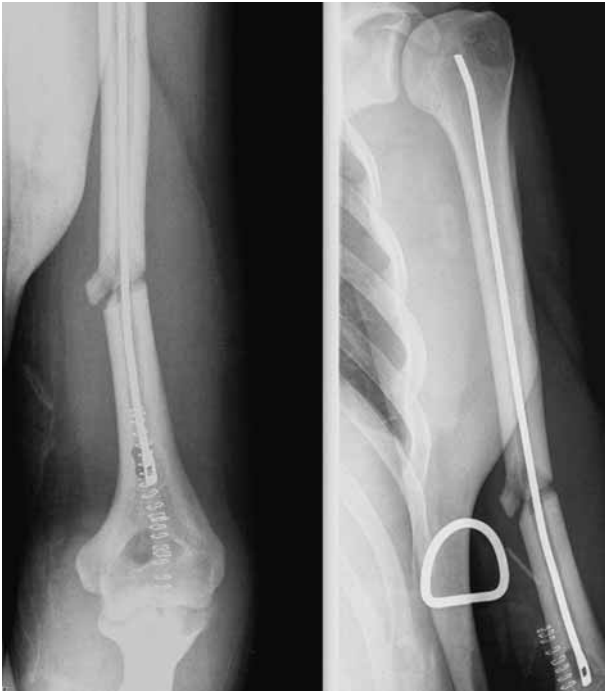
Radiograph showing the humeral fracture immediately after osteosynthesis with an Ender nail.
